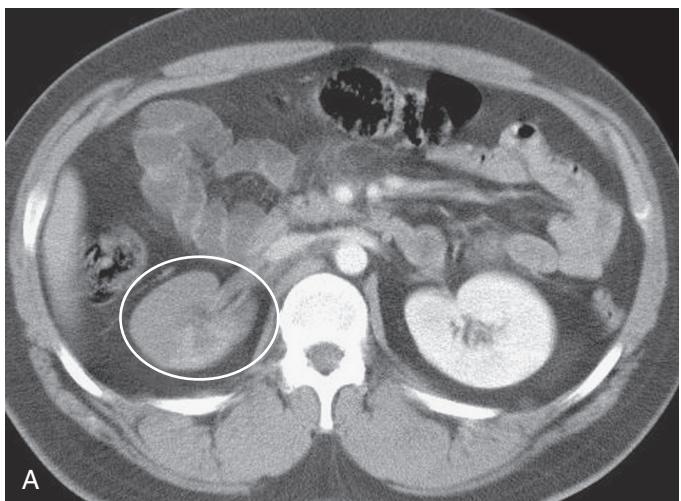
(A) CT shows lack of perfusion to the right kidney (circle) due to injury of the right renal artery after a fall from a height. (B) Angiography shows an intimal tear of the right renal artery (circle). Management with an endovascular stent was successful.
